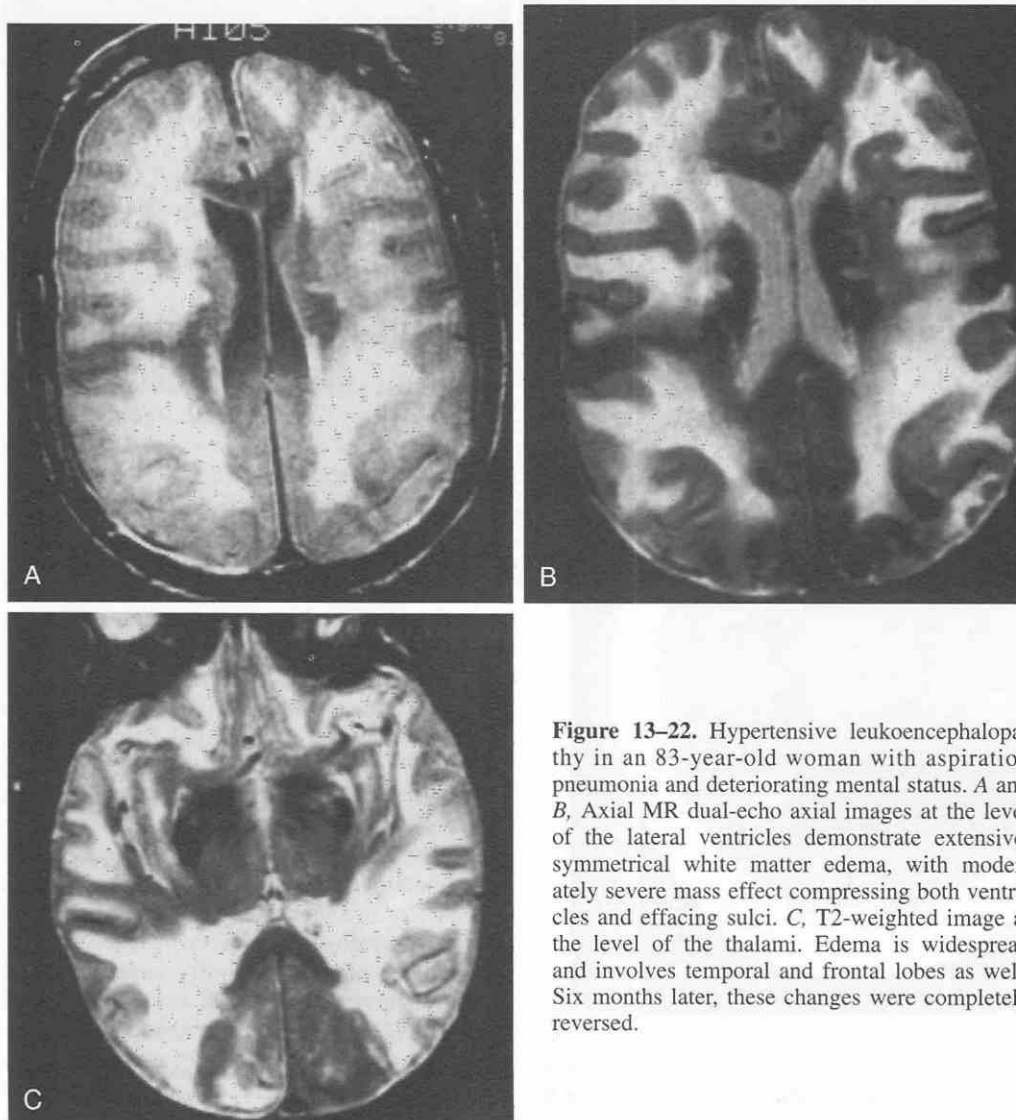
Hypertensive leukoencephalopathy in an 83-year-old woman with aspiration pneumonia and deteriorating mental status. A and B, Axial MR dual-echo axial images at the level of the lateral ventricles demonstrate extensive, symmetrical white matter edema, with moderately severe mass effect compressing both ventricles and effacing sulci. C, T2-weighted image at the level of the thalami. Edema is widespread and involves temporal and frontal lobes as well. Six months later, these changes were completely reversed.
